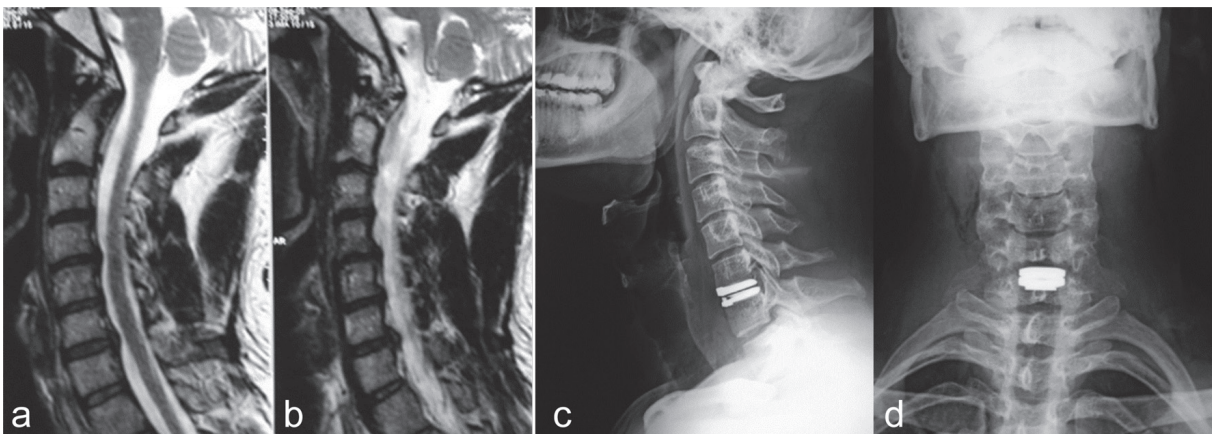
Preoperative MRI (a, b) and postoperative x-rays (c, d) of a patient with PCM disc prosthesis.
